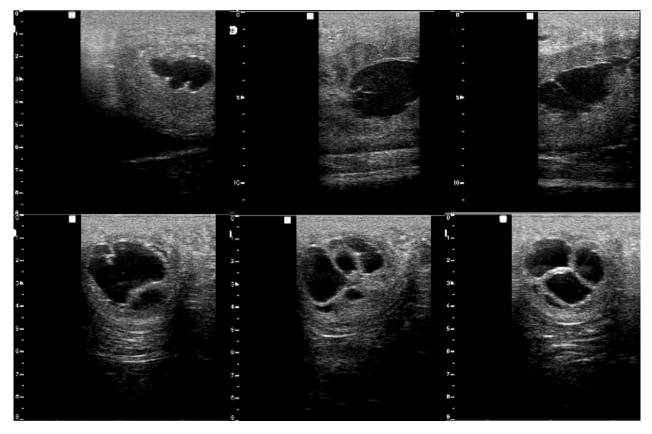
Ultrasonographic appearance of uterine lymphatic cysts.
